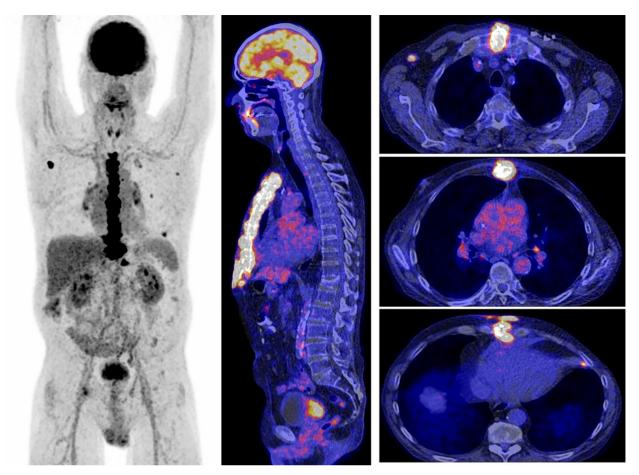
FDG-PET/CT (left MIP image, middle sagittal FDG-PET/CT fusion image, right transaxial fused PET/CT images) in a patient with osteomyelitis of the breast bone with soft tissue infection ventral of the breast bone, mediastinitis, multiple septic lung emboli, and reactive lymph nodes.
